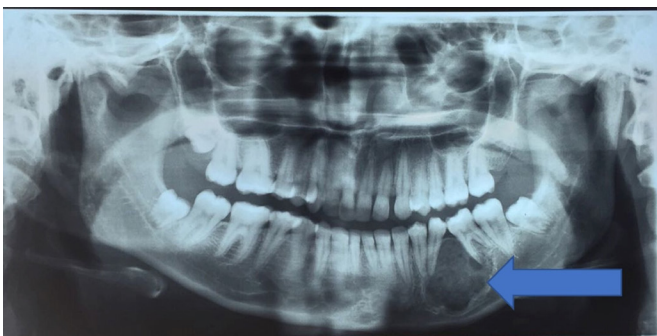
Panoramic radiograph showing the well-defined mixed lesion with sclerotic scalloped margins on the left body of the jaw. The lesion extended vertically from the alveolar margin to the inferior border of the jaw, encompassing the periapical region of teeth #34, #35 and #36. The inferior alveolar canal showed inferior displacement. Displacements of the roots of teeth #35 and #36 were noted.
